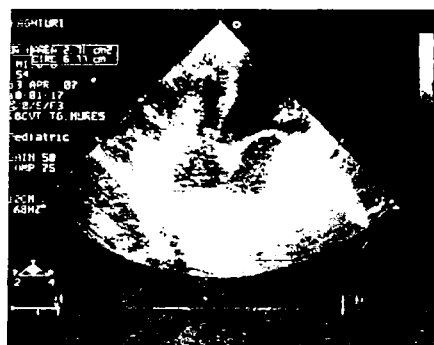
Apical four chamber - large vegetations on tricuspid leaflets
